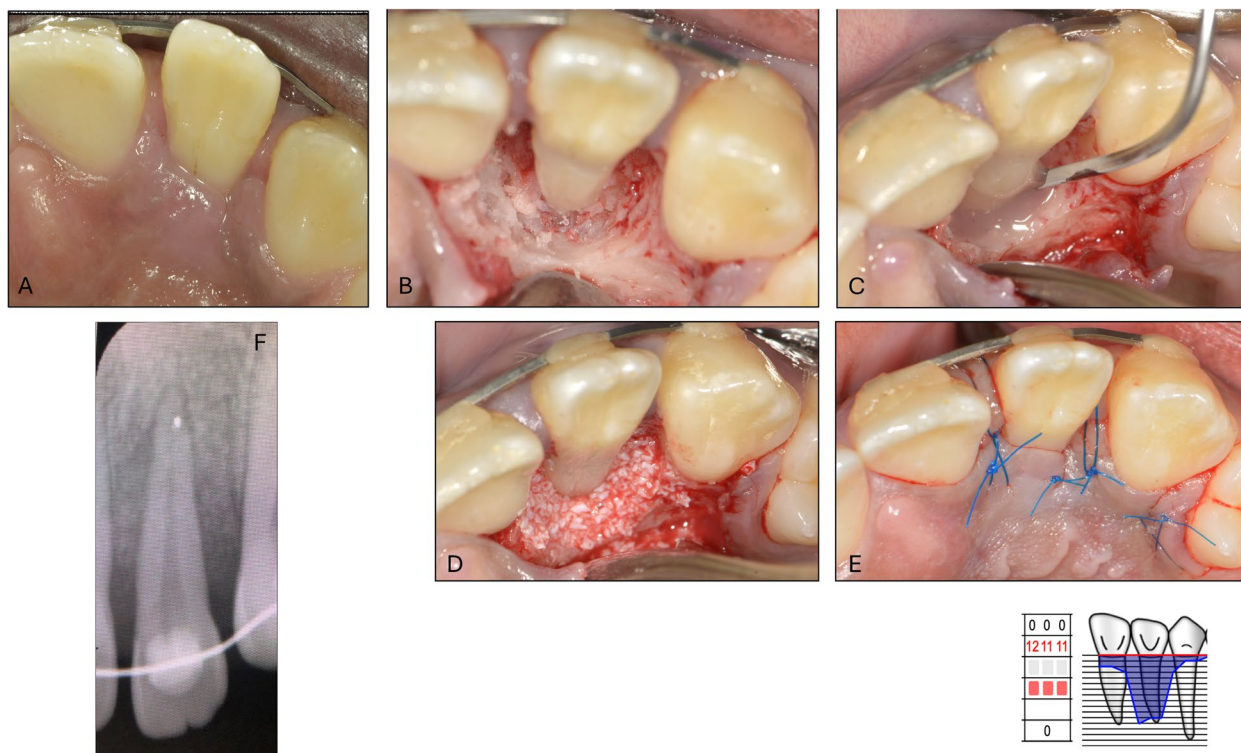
Regenerative therapy: view at the periodontal re-evaluation, 2-months after the initial treatment (a); large and deep 3-walls intra-bony defect (b); application of EMD (c); application of DBBM (soft tissue support, osteoconductive) (d); sutures (e); radiographic image at the 2-month follow-up (f)
